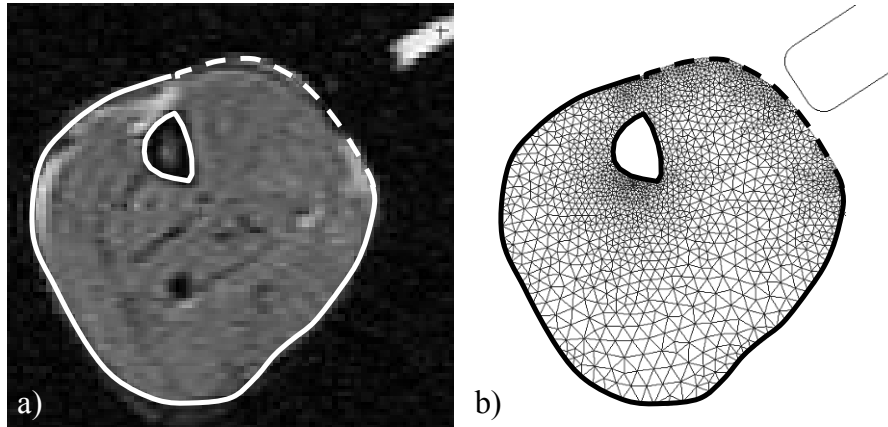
a) Transversal MR image of lower limb underneath the indenter, and b) corresponding mesh. In the computational model, nodes on the solid contour were fixed in all directions and nodes on the dashed contour were free to move.
